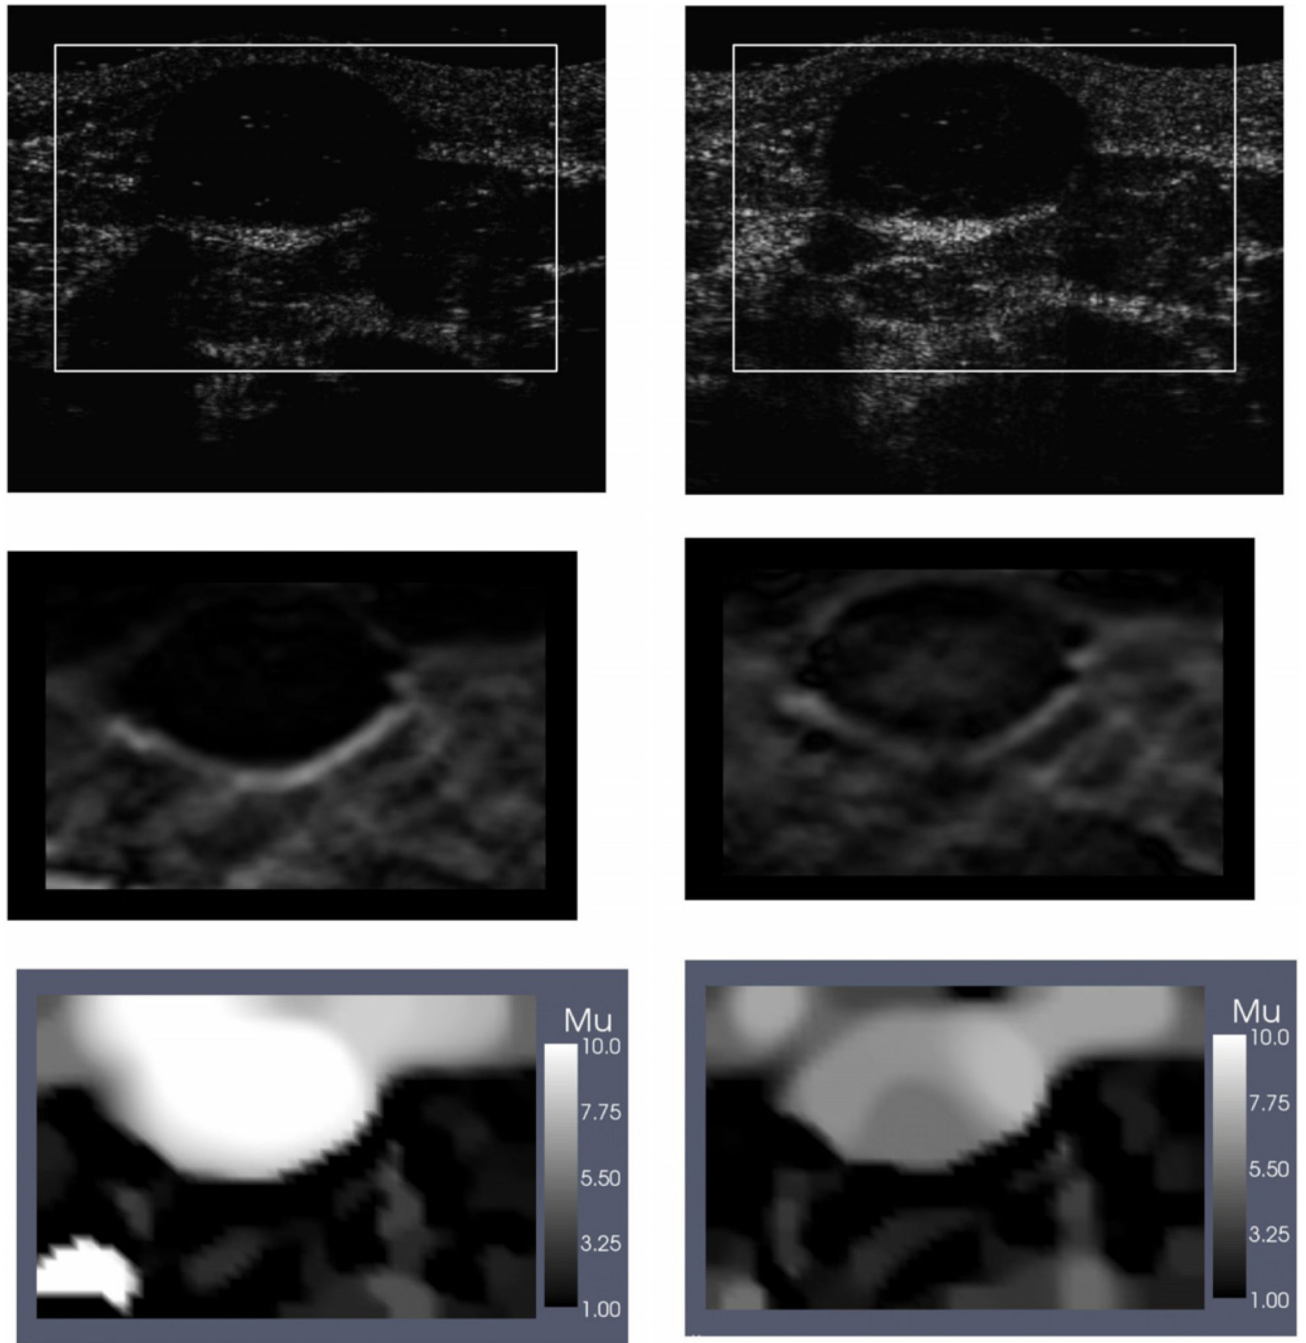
Images for fibroadenoma. Left column: images at small strain; right column: images at large strain. Top row: B-mode ultrasound images; middle row: axial strain image; bottom row: relative shear modulus (secant) images.
